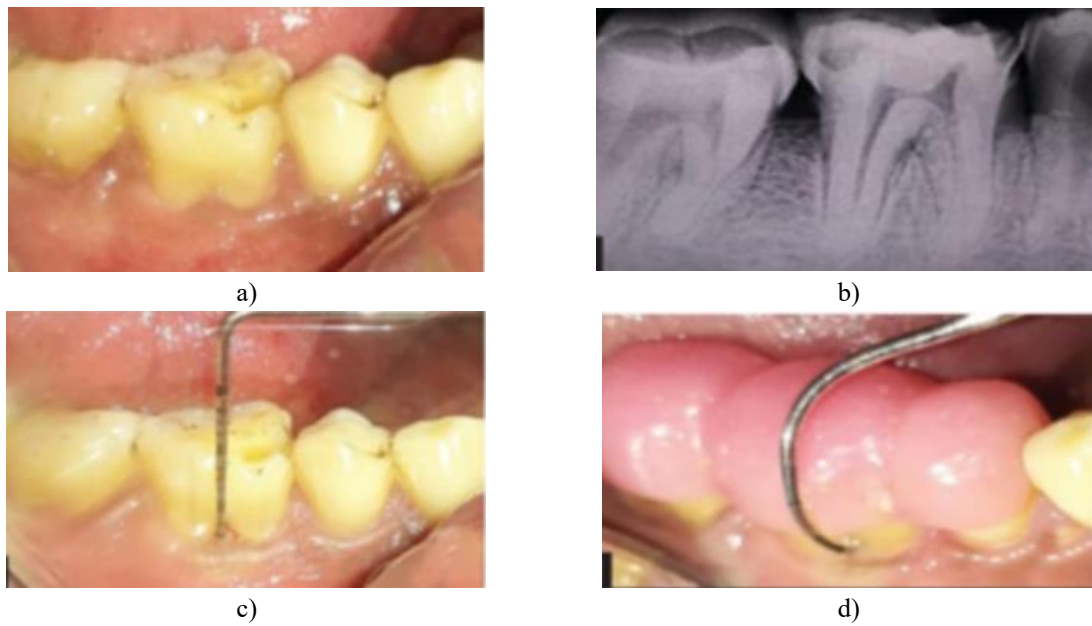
(a) Post-operative image of control site, (b) Post-operative intraoral periapical radiograph of the tooth with grade II furcation, (c) Postsurgical measurements of vertical probing depth, (d) Postsurgical measurements of horizontal probing depth
